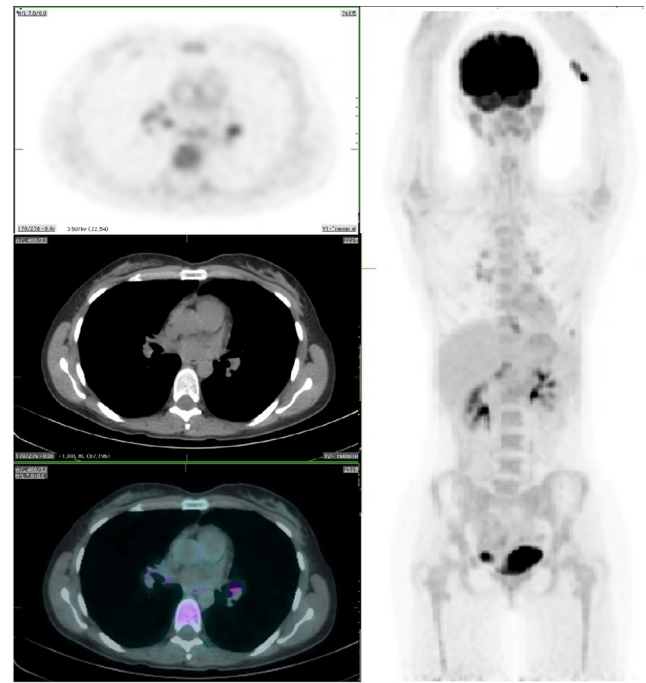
MIP and axial PET, CT, and fused PET/CT images of progress PET/CT performed 5 months following diagnosis showed significant metabolic and anatomical response in the previously FDG-avid multiple nodal stations above the diaphragm and in the spleen.
